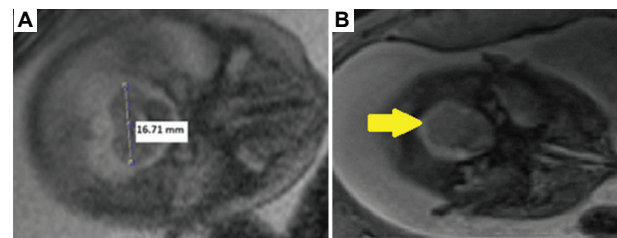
Cerebellar hypoplasia and dysplasia on fetal MRI. (A) Axial TRUFI image shows cerebellar hypoplasia based on TCD for this gestational age. (B) Axial HASTE image shows a dysmorphic cerebellum (yellow arrow).
